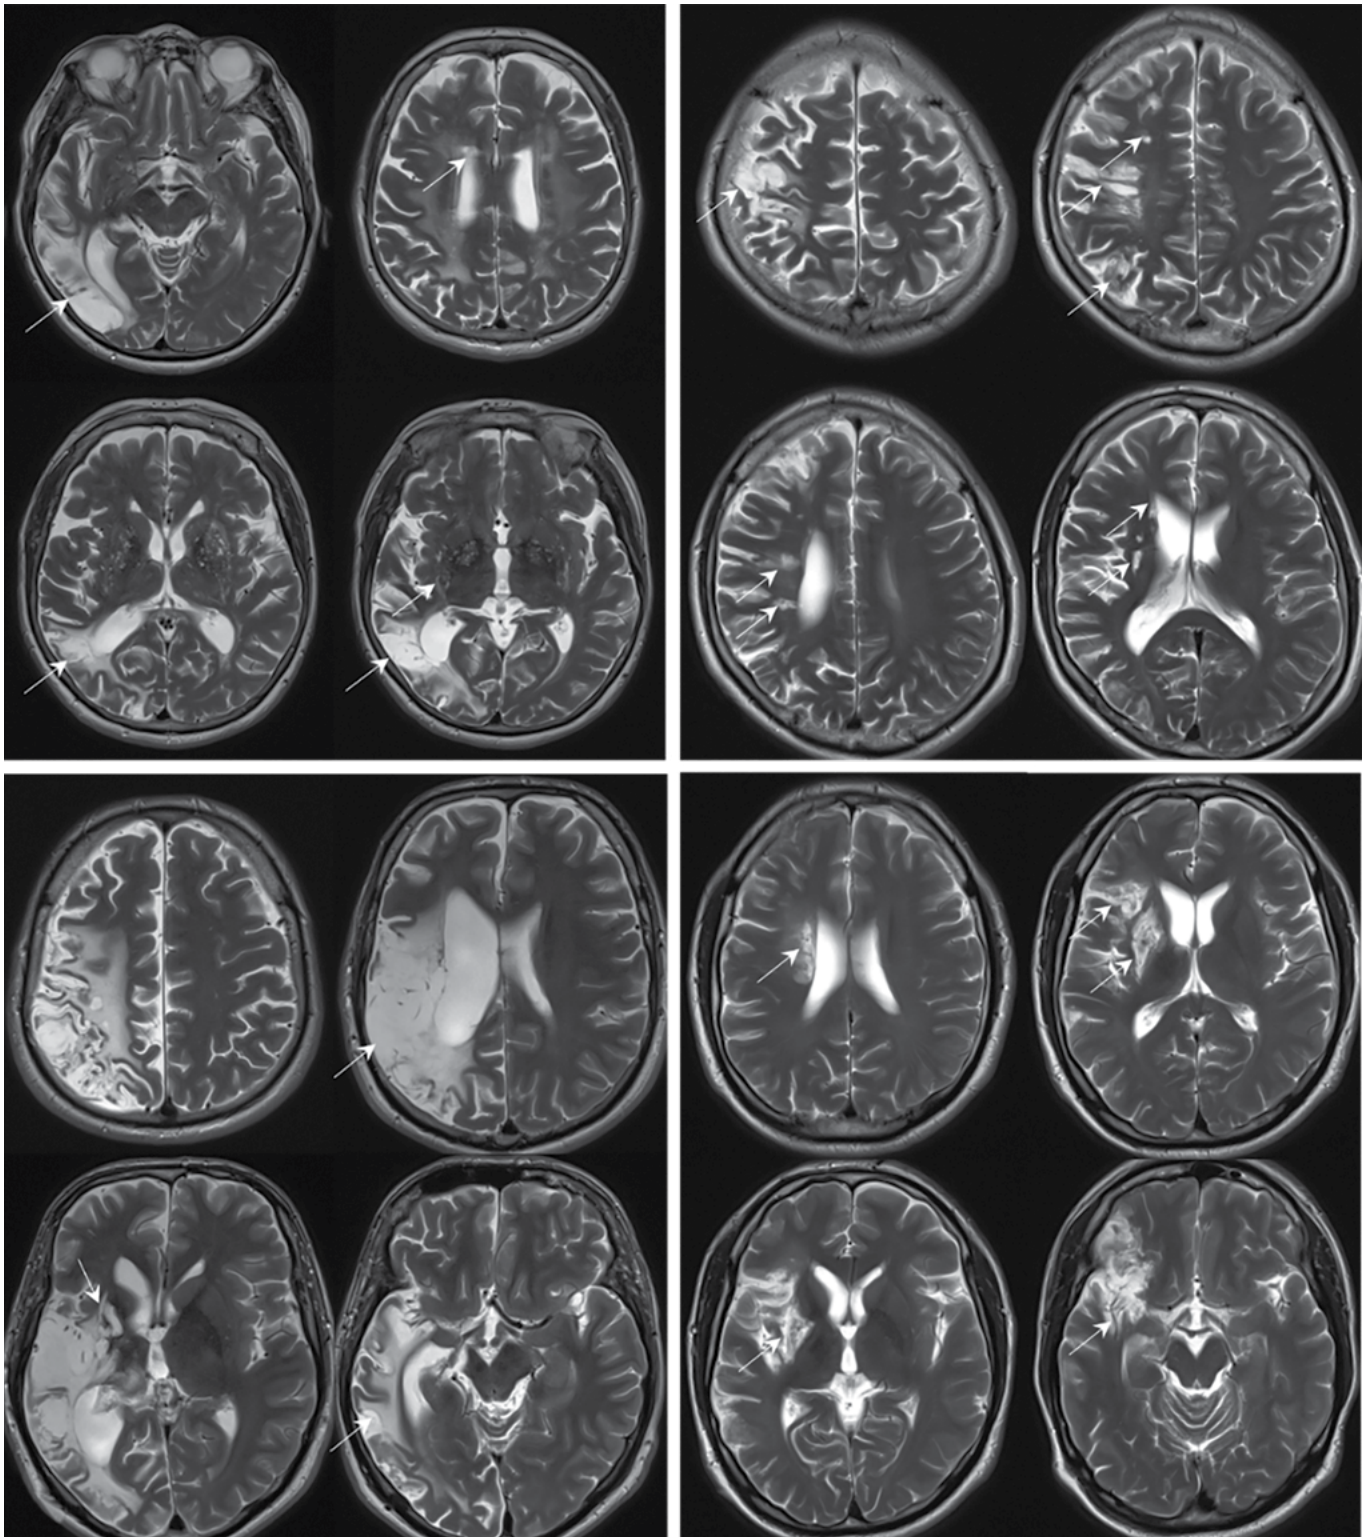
Brain MRI of patients with ET; axial plane T2-weighted images. In all cases, massive post-infarction changes are found in the cortex, underlying and deep white matter, and basal ganglia (post-infarction changes are indicated by arrows).
